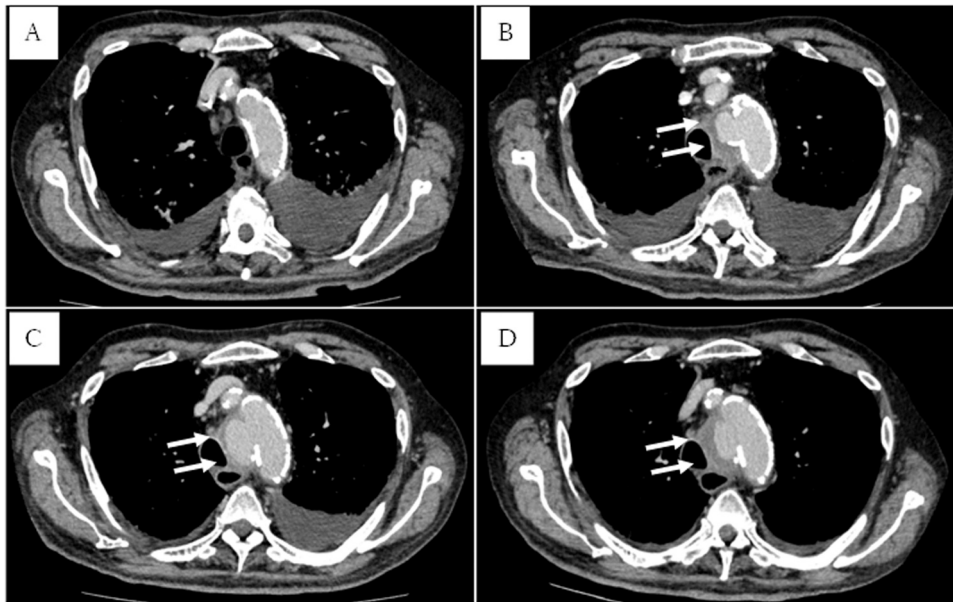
Contrast-enhanced computed tomography findings, A: Day 34, no aortic abnormality, B: Day 68, 29-mm aneurysm in the aortic arch, C: Day 90, aortic aneurysm increased in size (42 mm), D: Day 111, slight enlargement of the aneurysm (44 mm) and increase in mural thrombi.
